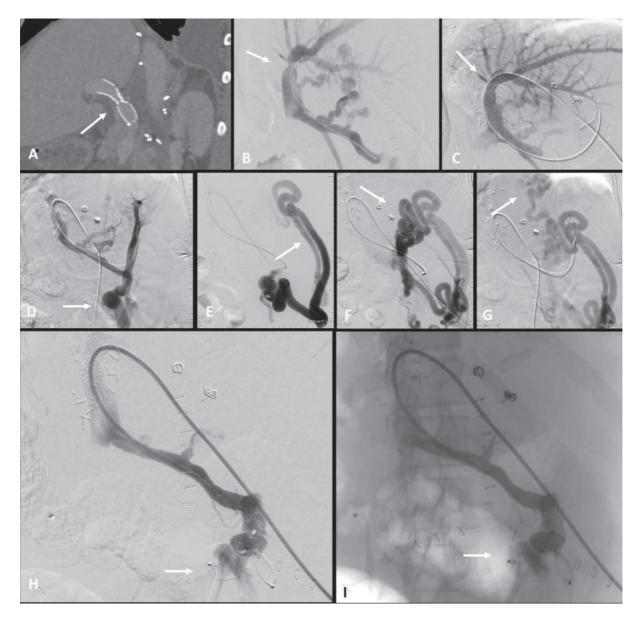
Computed Tomography 1 Month After First Intervention Because of Suspicious In-Stent Stenosis Findings in Doppler Ultrasonography and Presence of Portal Hypertension (same patient as in Figure 4)
